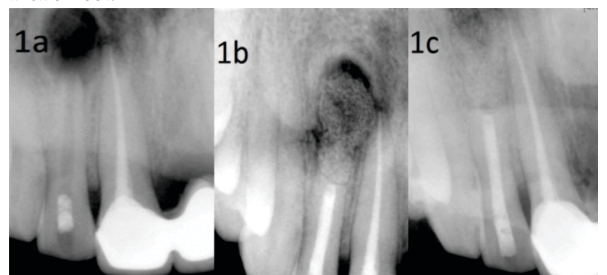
(a) preoperative x-ray, (b) after enucleation of cyst and bone graft placement (c) follow up after 6 months
